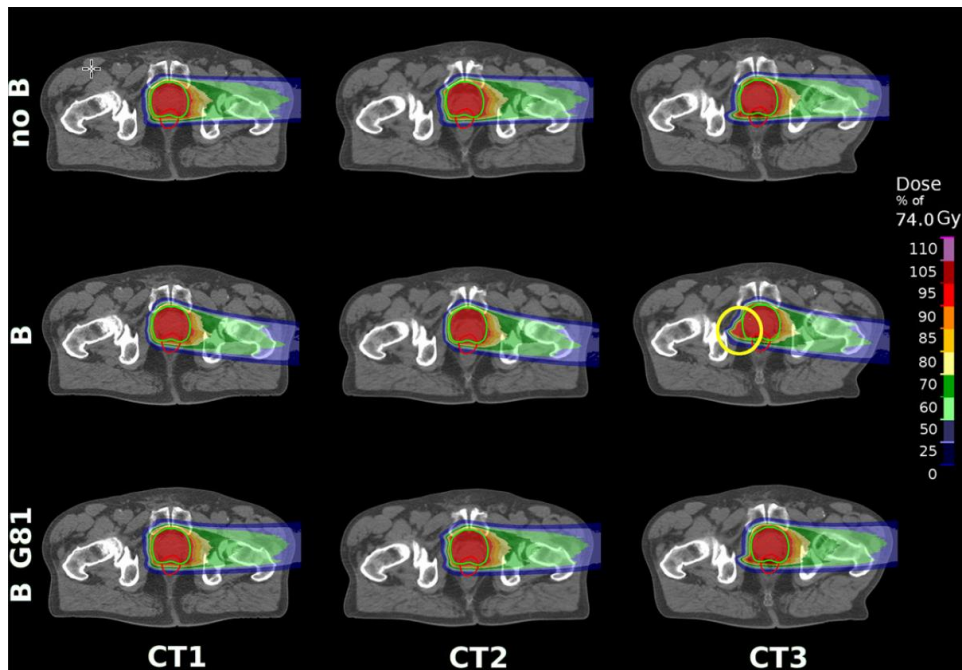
Proton dose distributions for an exemplary prostate patient optimized on CT1 and recalculated on CT2/3 to infer the robustness against inter-fractional anatomical changes for different scenarios: Treatment without B-field (top row), as well as treatment in presence of a 1.5 T B-field perpendicular to the incident beam using gantry angles of 90° (middle row) and 81° (bottom row). Robustness for the B-field scenario with 81° gantry angle was similar to the conventional scenario without B-field, while reduced robustness was observed for a gantry angle of 90° in presence of the B-field. A substantial overshoot on CT 3 is indicated by the yellow circle.
